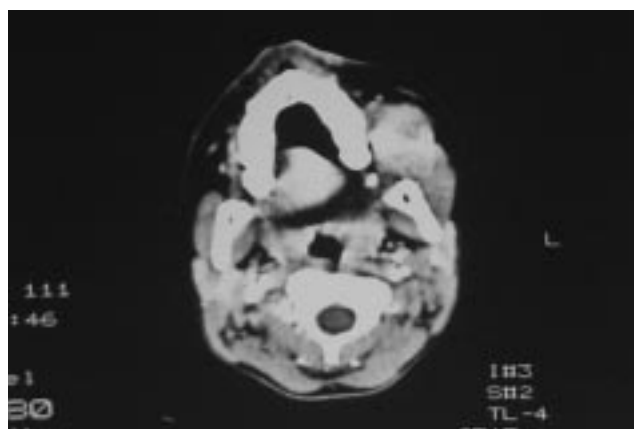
Computed tomography scan showing an intensely enhancing, well-defined mass in the subtemporal and buccal region.
